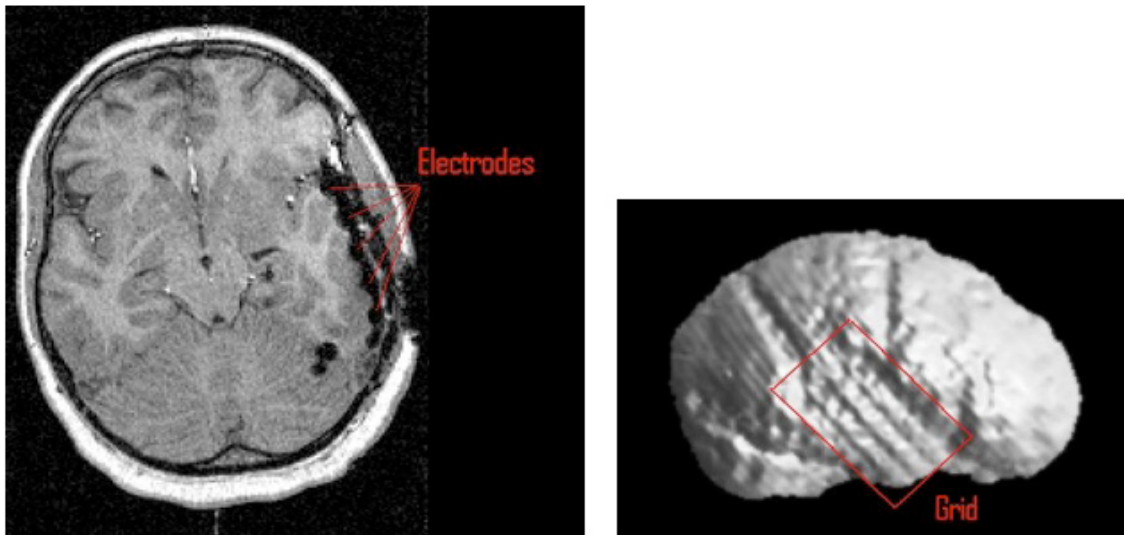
Electrode locations seen in a axial MRI slice (left) and on the outer surface of the brain (right) of the subject.
